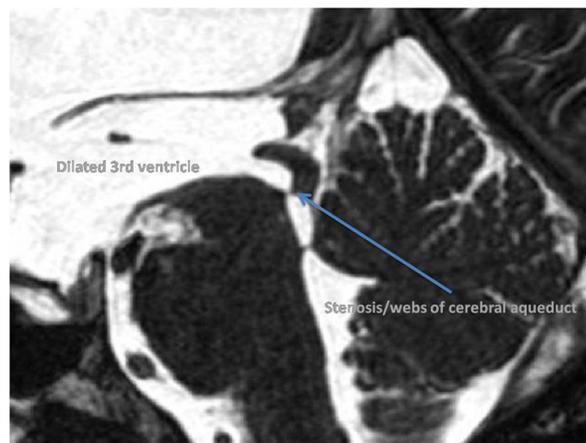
MRI, T2 FIESTA protocol, sagittal view, delineating anatomy of ventricles and CSF flow.
